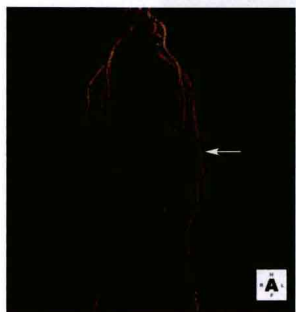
Persistent sciatic artery. Three-dimensional CTA volume-rendered image (anteroposterior view) shows occlusion of the distal left superficial femoral artery. The left popliteal artery is supplied by a persistent left sciatic artery fed by the internal iliac artery (arrow). (Reprinted from Cohen E, Doshi A, Lookstein R. CT angiography of the lower extremity circulation with protocols. In: Mukerjee D, Rajagopalan S, eds. *CT and MRI angiography of the peripheral circulation: practical approach with clinical protocols*. London, UK: Informa Health Care, 2007:143, with permission.)
